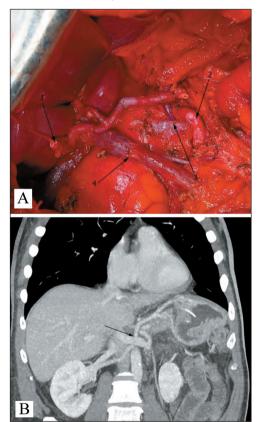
A. TP with PMR: 1 – the stump of the common bile duct; 2 – SMA; 3 – the anastomosis of the gastric coronary vein to the left renal vein; 4 – the portomesenteric anastomosis. B. The CT scan of the same patient at postoperative day 7. The arrow points to the well-functioning venous anastomosis. Note: created by the authors Pис. 2. А. ТП с ПВР: 1 – культя общего желчного протока; 2 – верхняя брыжеечная артерия; 3 – анастомоз левой желудочной и левой почечной вен; 4 – портомезентериальный анастомоз. Б. КТ скан того же пациента на 7-е сут после операции. Стрелка указывает на хорошо функционирующий венозный анастомоз.
